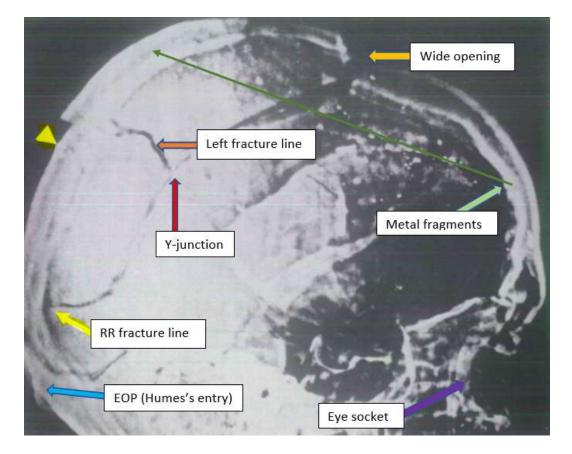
This is the HSCA-enhanced, "right" lateral skull X-ray, with the eye socket on the right. "Humes's entry" represents the posterior impact site, per the Warren Commission testimony of Humes and his colleagues. The lower yellow arrow is RR's self-identification of his proposed "transverse fracture of the right occipital bone just slightly above the EOP...." His upper yellow arrow identifies an authentic metal fragment, which he correlates with the 6.5 mm object on the AP X-ray. This upper yellow arrow is near the cowlick area, which the HSCA chose for its posterior entry site. My blue arrow identifies the approximate site of the EOP. The long, thin green line identifies the metallic trail of debris. Dr. Michael Chesser and I have both observed multiple, tiny metal fragments very near the forehead (light green arrow). See the text for discussion of the "Y-junction" and the "Left fracture line."
